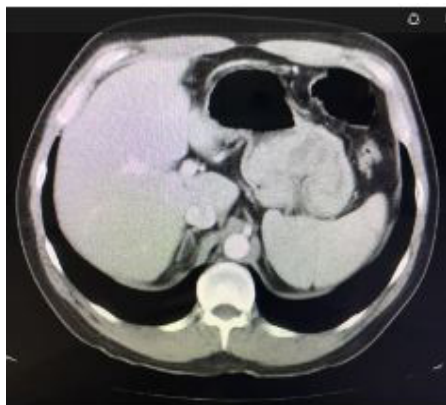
Abdominal CT Scan Showing Gastric Mass. Axial Section.
